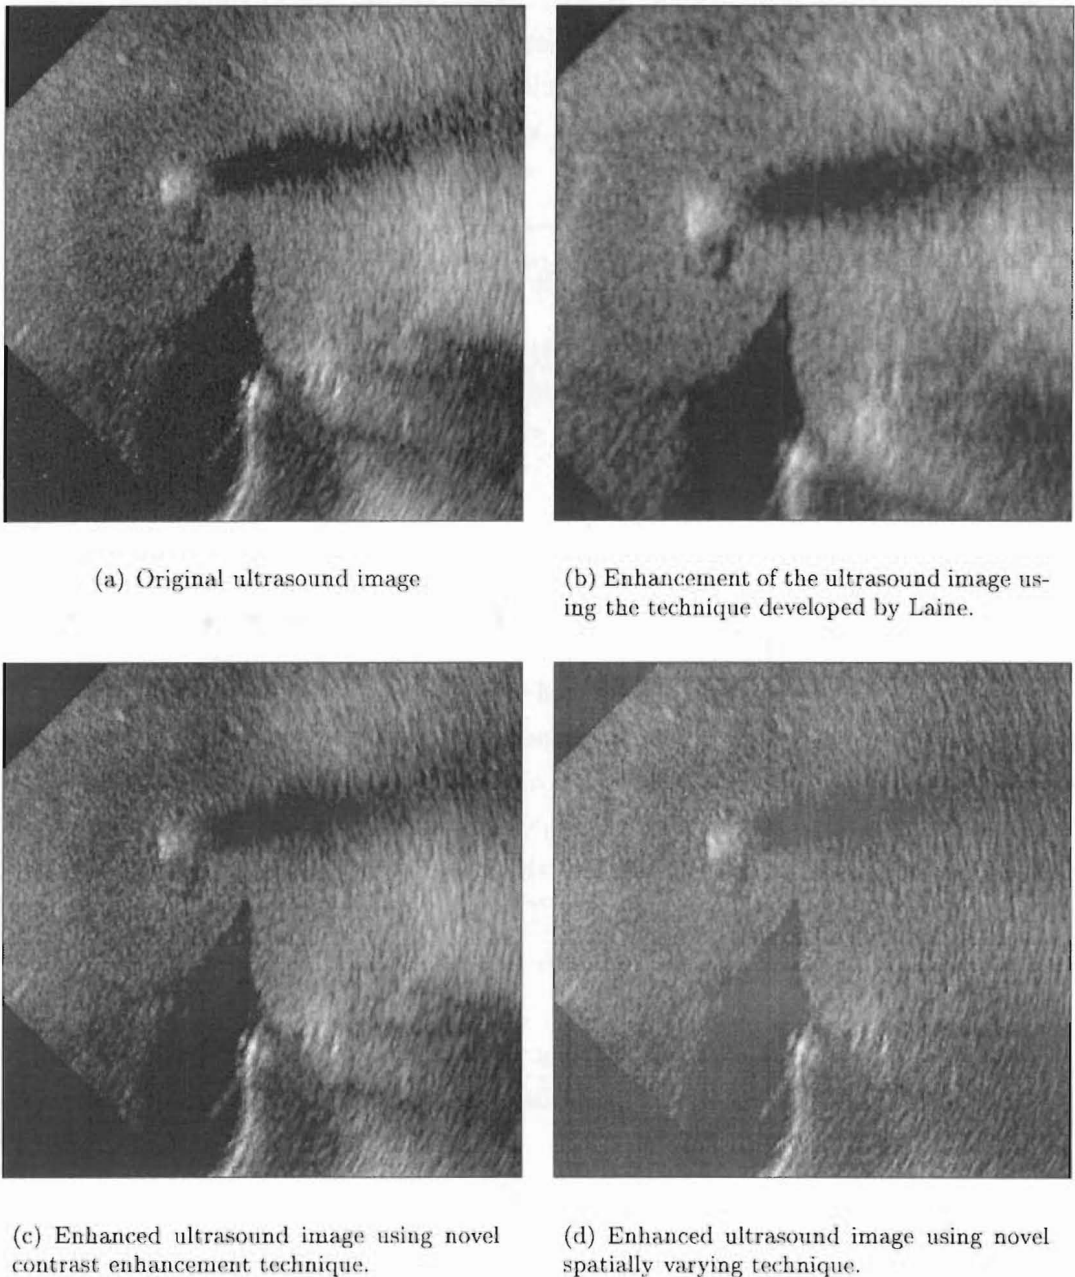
Results of enhancement using various techniques. (a)Original ultrasound image (300x300). (b) Image enhanced using technique from Laine *et al.* [1995]. This image is 256x256 cropped from the original. (c) Image enhanced using contrast enhancement obtained using parameters: $K_1 = 0.9$, $K_2 = 1.5$, $k = 1$, $W_d = 0.1$, $W_e = 3$, $N_d = 1$, and $N_e = 1$. (d) Image enhanced using spatially varying contrast enhancement with the same parameters as (c), except for $k = 1.08$.
